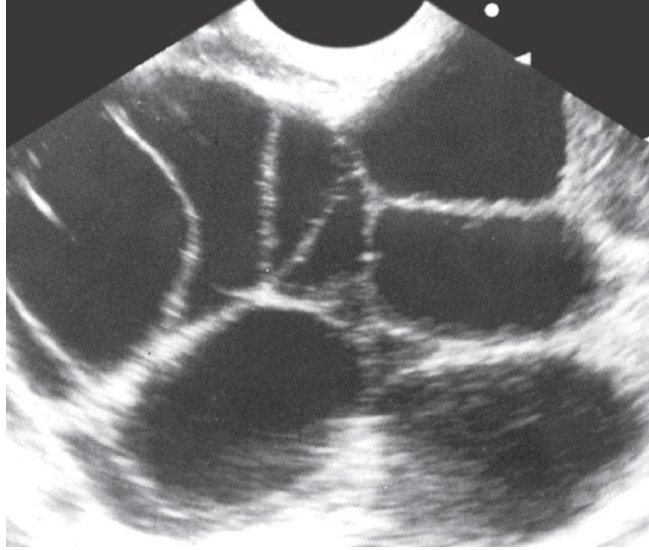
Ultrasonographic view of ovarian hyperstimulation syndrome. Enlargement of the ovary with multiple follicles
